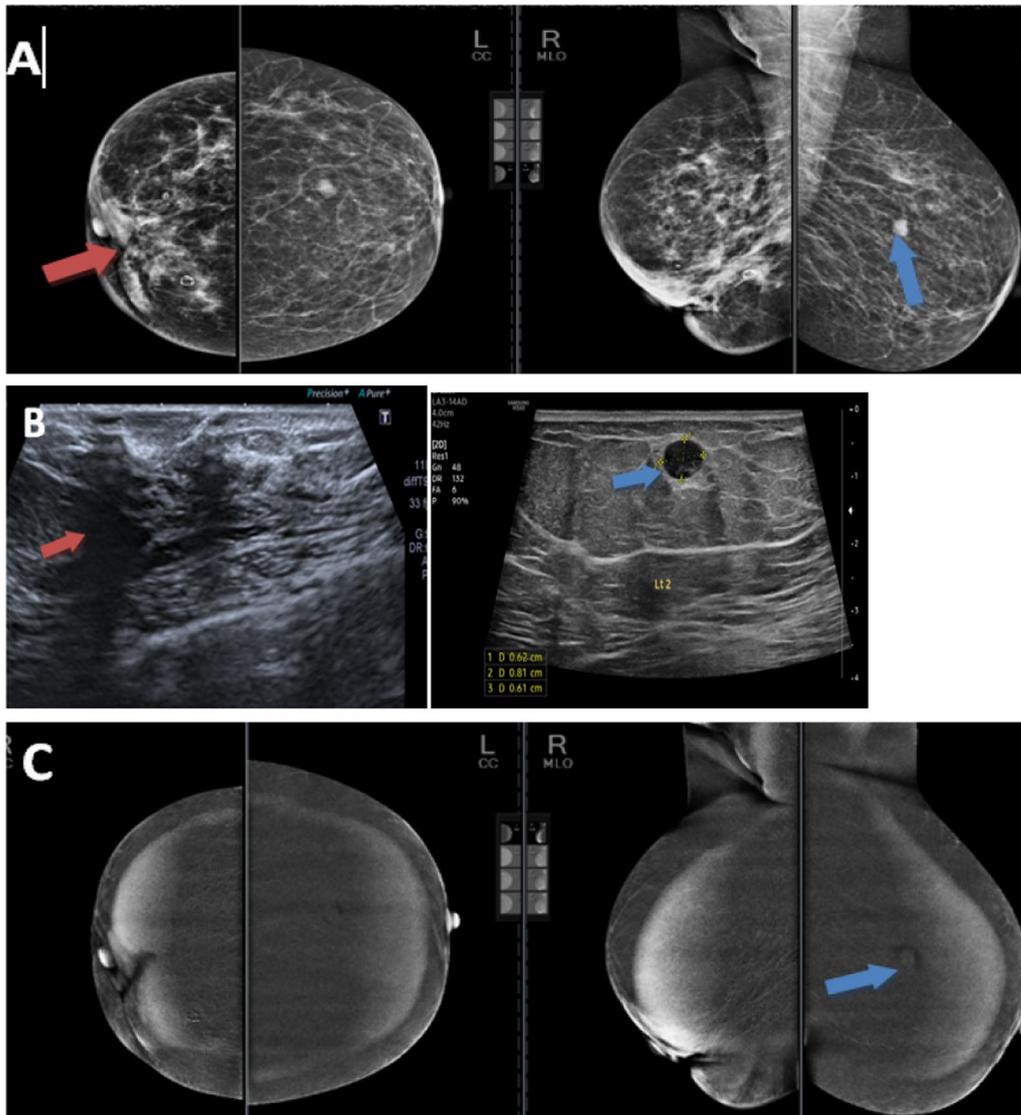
A 40-year-old asymptomatic female patient underwent right CBS for IDC grade II, presenting for her annual follow-up. A Mammography (CC and MLO views) revealed: Breast density ACR 'b'. Asymmetry is seen in the LIO of the right breast (red arrow) with skin thickening and nipple retraction. Multiple right radiolucent lesions with eggshell calcifications; oil cysts. Left UOQ well-defined ovoid-shaped isodense lesion (blue arrow). B Complementary ultrasound revealed: hypoechoic extensive operative bed scarring in the LIQ of the right breast (red arrow) and left UOQ well-defined oval-shaped parallel lesion (blue arrow). C Contrast-enhanced spectral mammography revealed: No operative bed-enhancing lesions, and left UOQ well-defined enhancing mass (blue arrow). Final Diagnosis: Right breast postoperative changes and Left UOQ fibroadenoma. Final comment: In this case, sonomammography showed suspicious operative bed changes with extensive scarring, while CESM could exclude operative bed lesions
